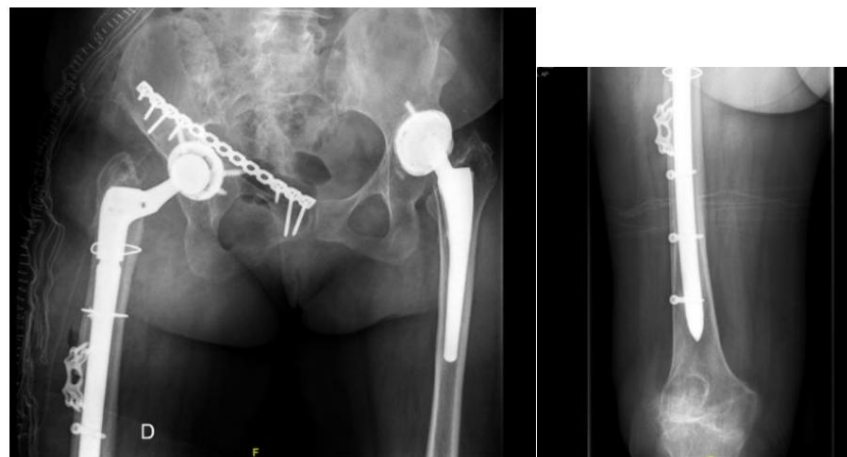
Postoperative AP pelvis and AP right femur X-ray.
